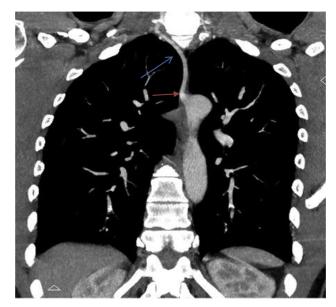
Case 1: Coronal oblique MIP image of CT scan of the chest showing proximal course of the aberrant right vertebral artery (blue arrow) from origin to cervical foramina. Notice the aneurysmal origin (red arrow).
